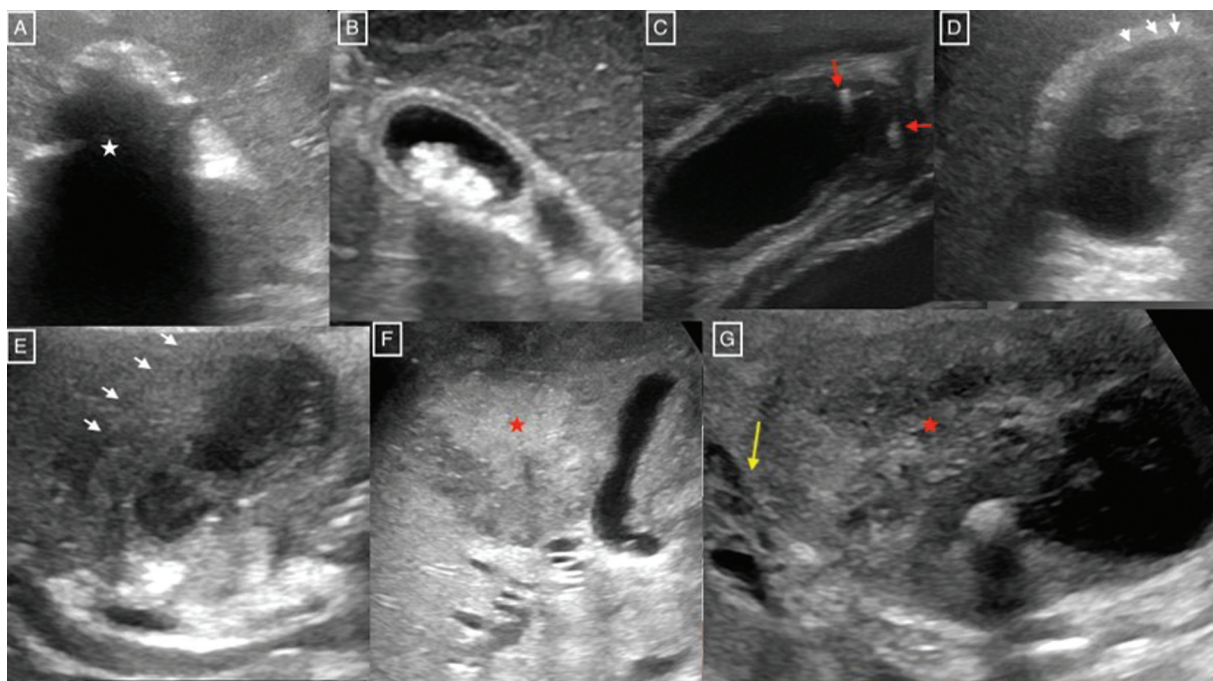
Transabdominal ultrasound images showing various categories of gallbladder reporting and data system (GB-RADS). (A) GB-RADS 0–Wall echo-shadow complex (asterisk) limiting adequate evaluation of the gallbladder wall. (B) GB-RADS 2–Symmetric circumferential mural thickening with layered appearance and cholelithiasis suggestive of typically benign thickening. (C) GB-RADS 2–Typical benign gallbladder wall thickening with intramural echogenic foci (arrow). (D) GB-RADS 3–Focal thickening without intramural features or layered appearance and preserved interface with liver (white arrow). (E) GB-RADS 4–Asymmetric circumferential mural thickening without layered appearance and with loss of interface with liver (white arrow). (F and G) GB-RADS 5–Asymmetric circumferential mural thickening without layered appearance, loss of interface with liver, and associated liver mass contiguous with mural thickening (asterisk). Note the biliary involvement by the mass (G, arrow).
